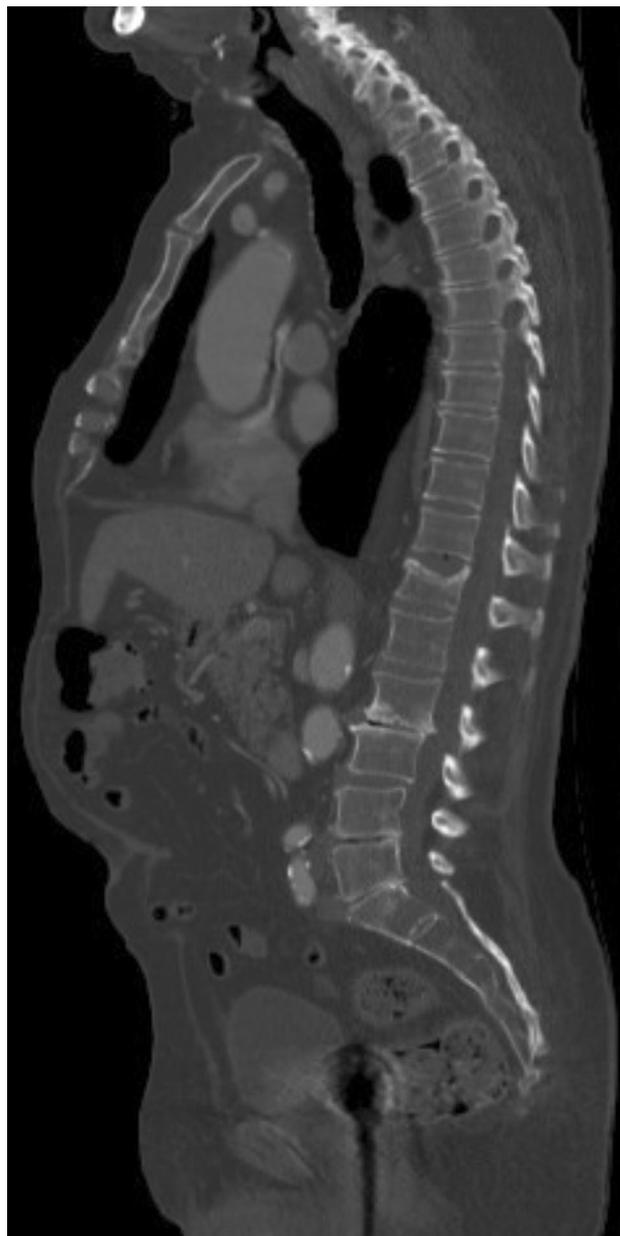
Sagittal reformat of chest, abdomen and pelvis computed tomography scan visualizing the entire thoraco-lumbar spine. A fracture at T12 was identified
